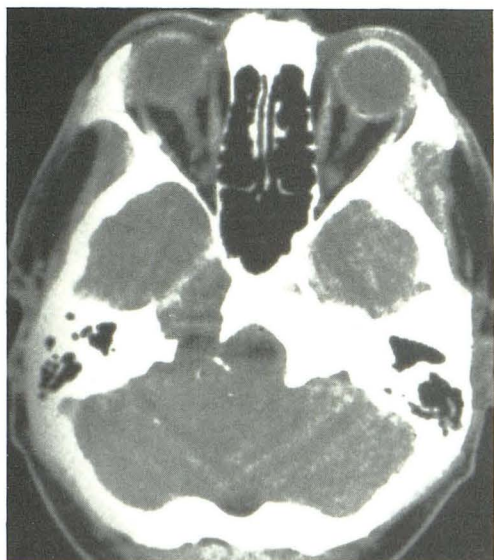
Case 3: Axial CT scan of skull base at bone window settings demonstrates a lytic lesion in right petrous apex with foci of calcification in associated soft-tissue mass extending into posterior cranial fossa.
